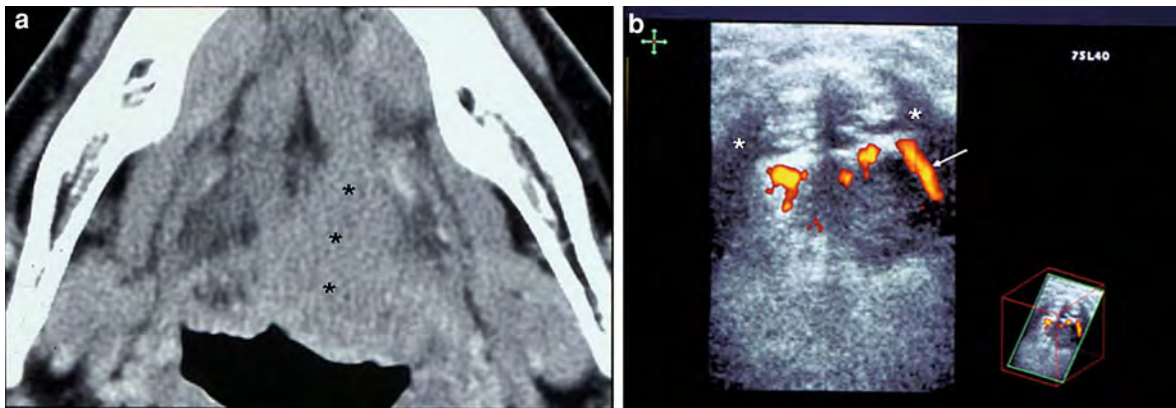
CT of a 56-year-old man with an oropharyngeal (T4) squamous cell carcinoma of the base of the tongue and deep tumor infiltration into the geniohyoid and genioglossus muscles of the floor of the mouth (*stars*) and midline crossing (*a*). The
